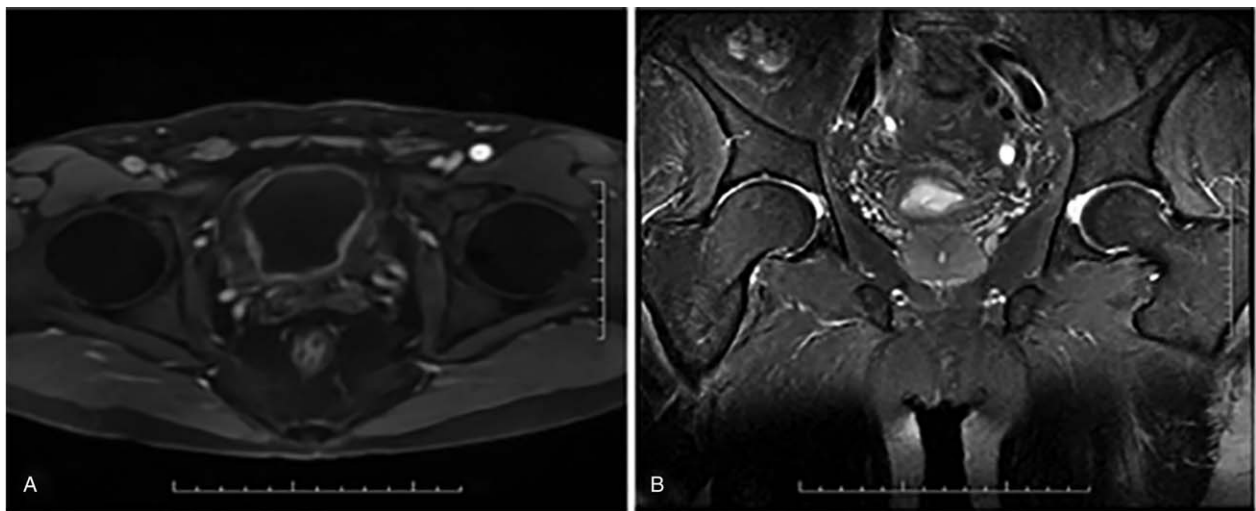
MRI concluded benign prostatic hyperplasia. MRI = magnetic resonance imaging.
